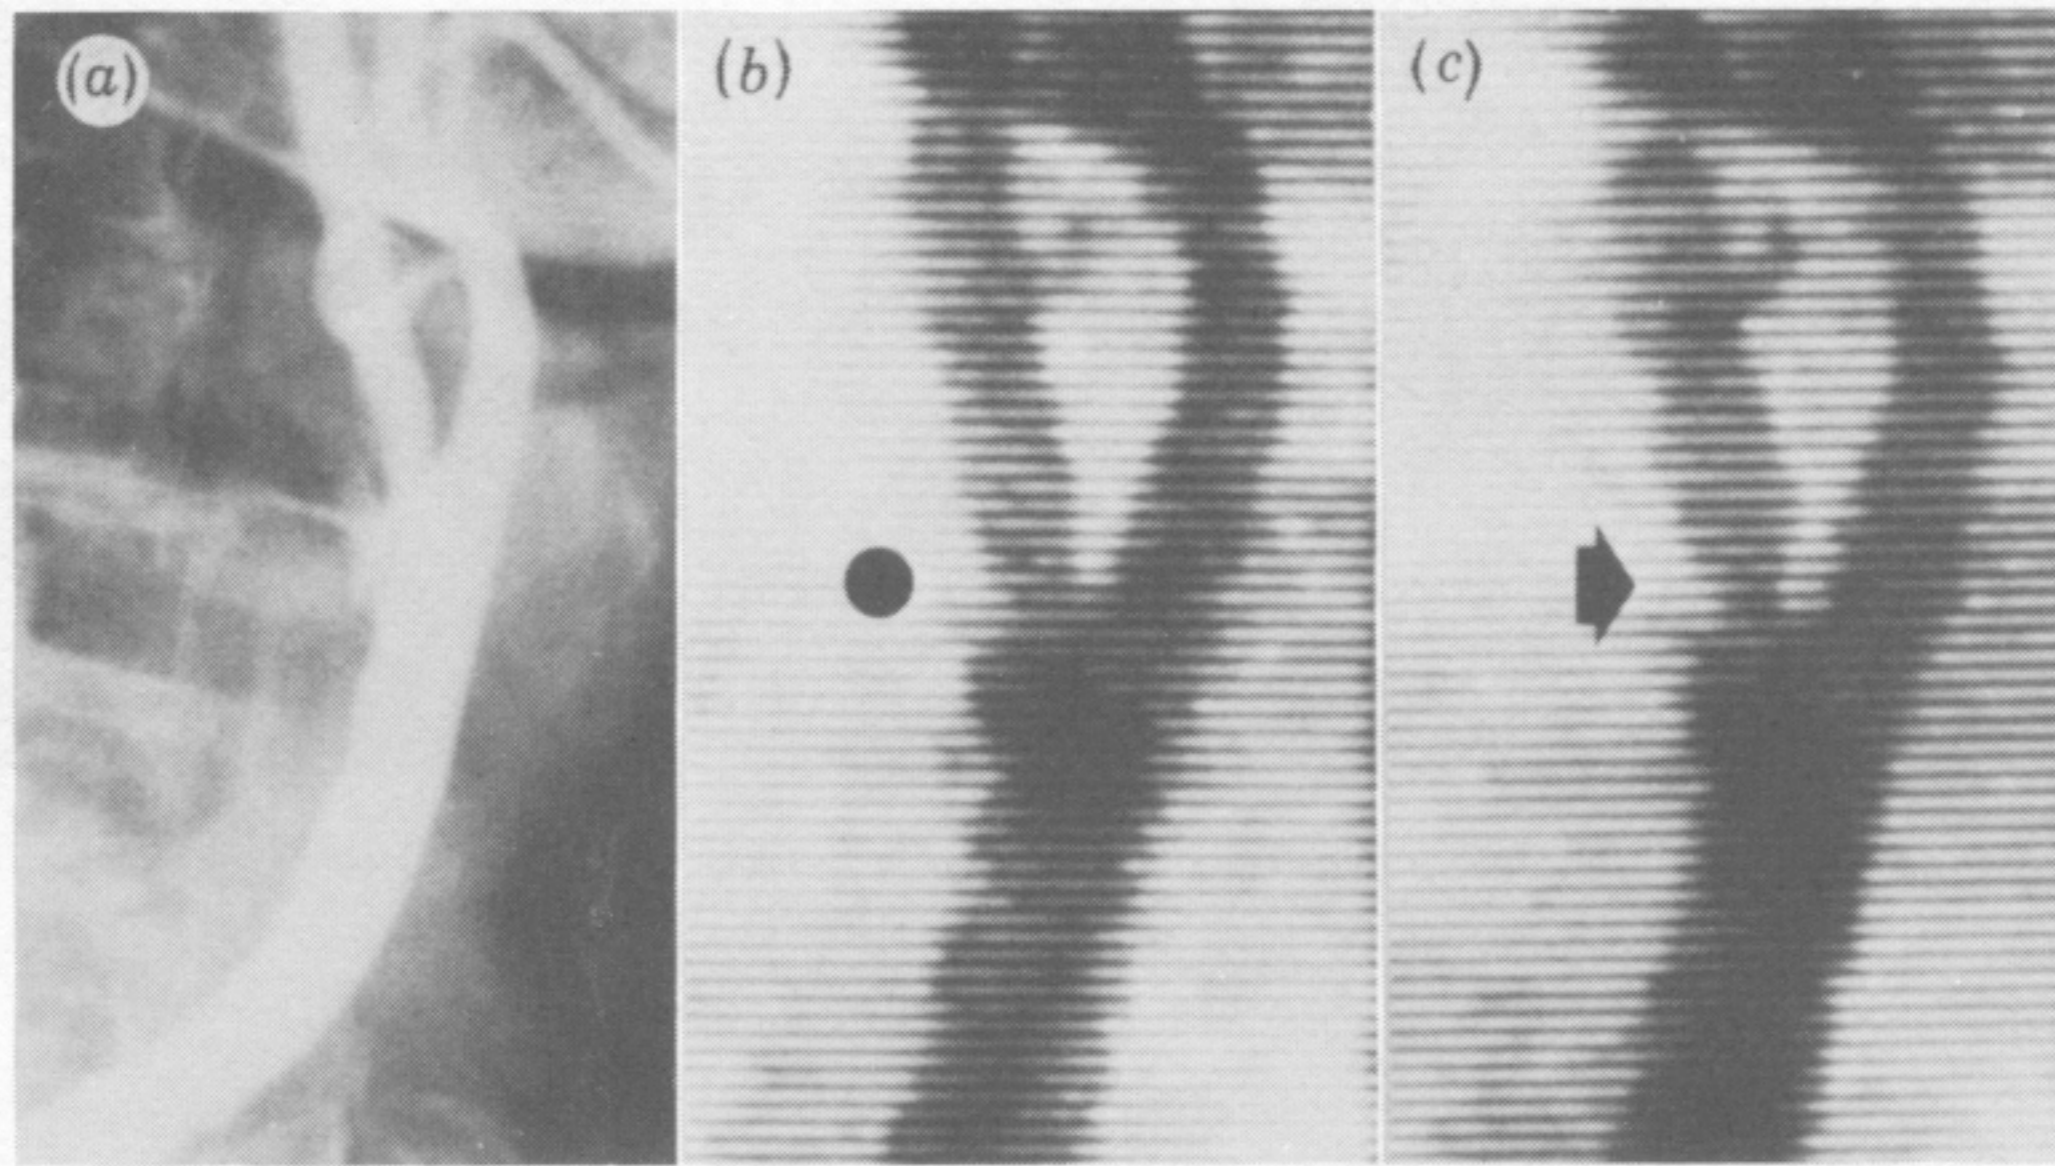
Single X-ray (*a*) and two video frames (*b*, *c*) of a carotid angiogram. The lesion arrowed is not so obvious in an earlier frame (dot) nor in the angiogram.
